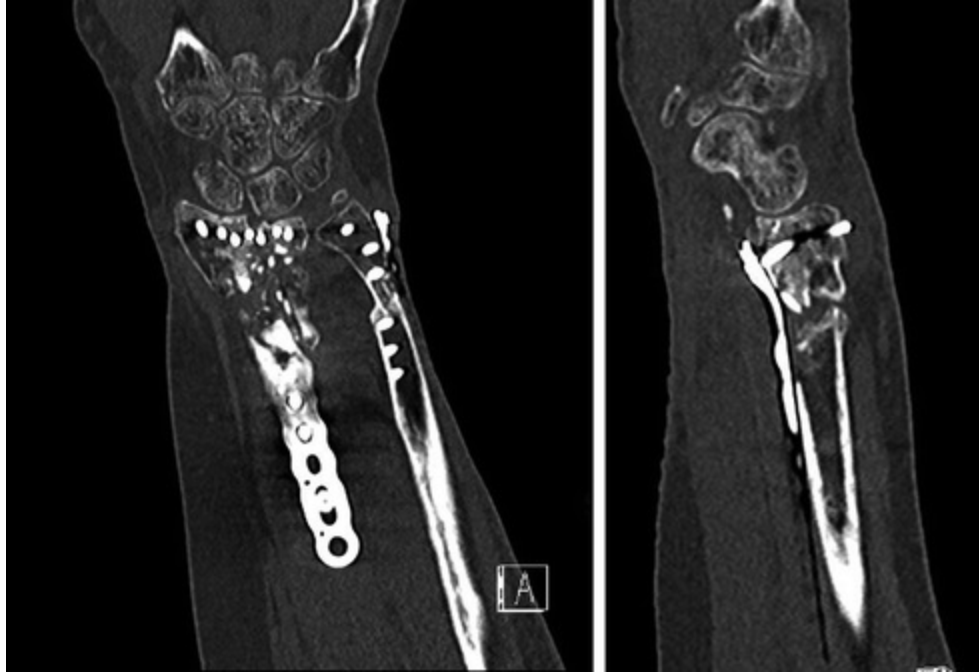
Computed tomography evaluation of distal radius nonunion after attempted fixation and allograft bone grafting for comminuted open fracture
